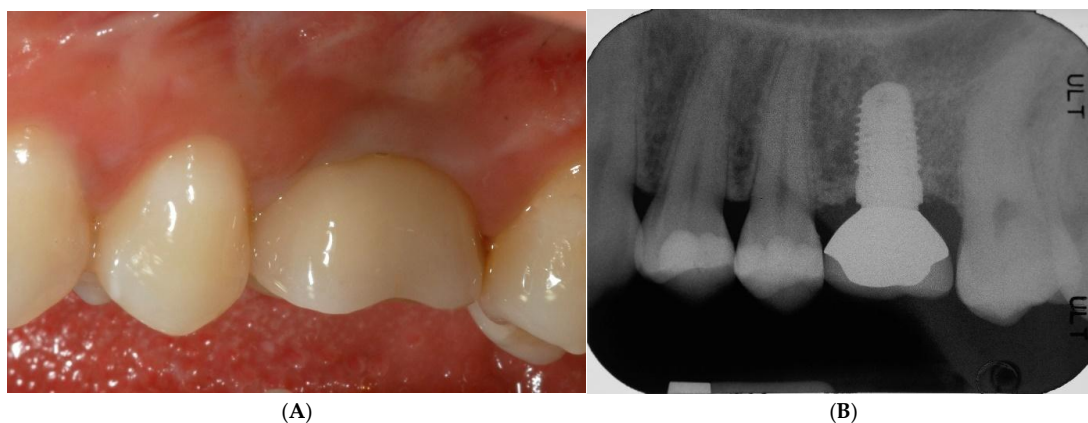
5-year clinical (A) and radiographic (B) follow-up after functional prosthetic loading showed augmented hard and soft tissues, which were well maintained.
